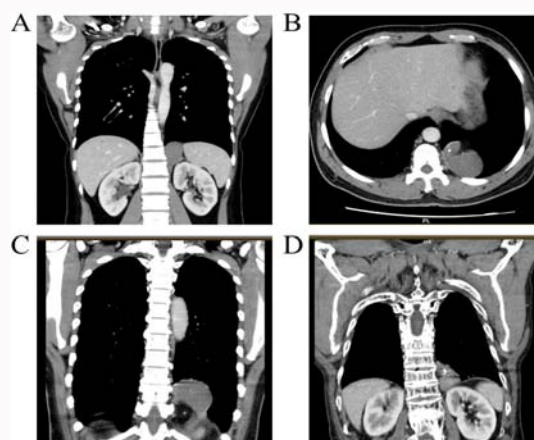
Thoracic CTs of patients. A) case 1, 51 years; B) case 2, 38years; C) case 3, 55 years; D) case 4, 56 years. CT showing lesions as soft tissue hypo-enhancing masses adhering to the left diaphragm, calcifications were present in four patients (combined linear and nodular).
